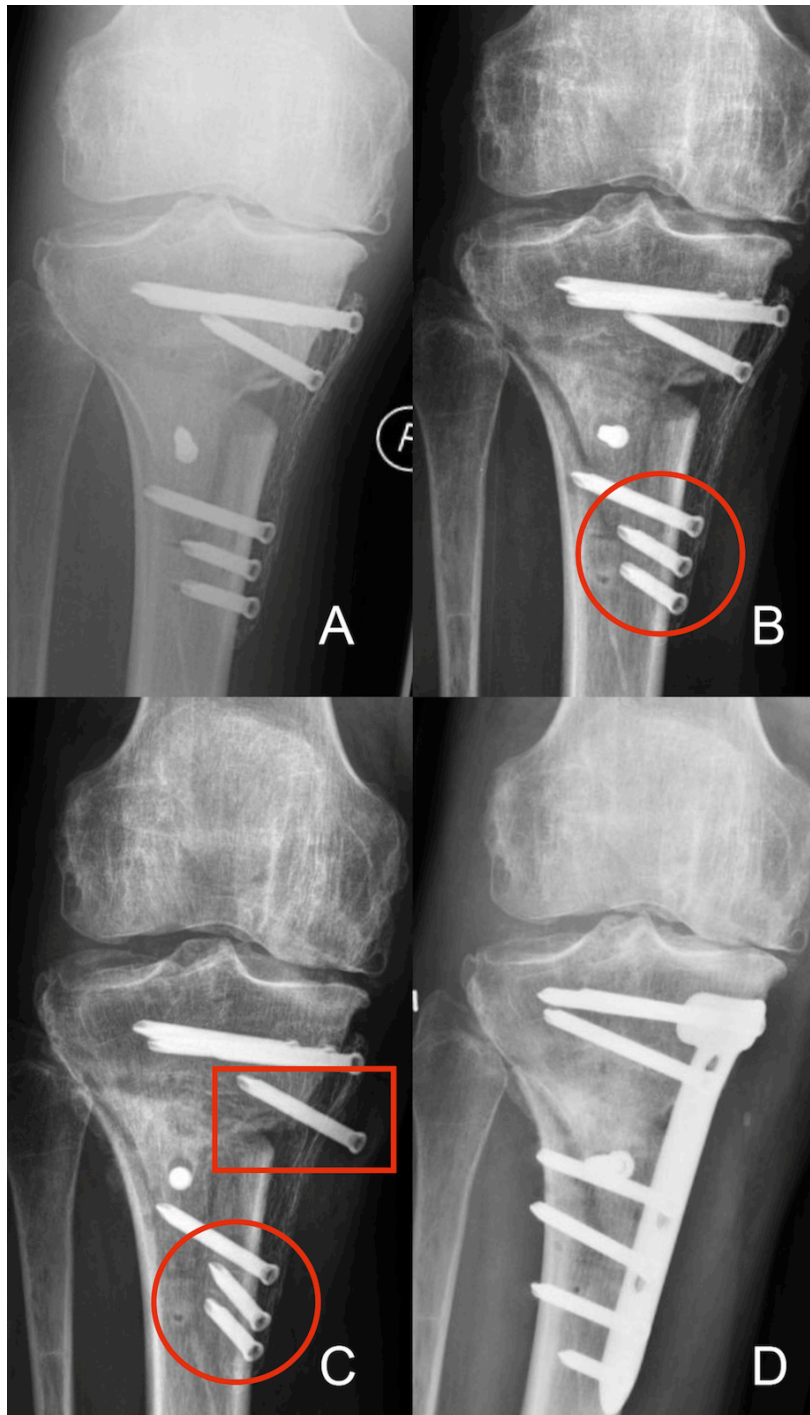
Postoperative AP radiograph at the inpatient stay (A) after ow HTO with the 2nd generation PEEKPower HTO-Plate® in a 49 year old sportsperson (height: 175 cm, weight: 76 kg, BMI: 25). The initial osteotomy gap in this case was 15 mm. Also minimal dislocation of the distal screws (red circle) was observed after he started bicycle training on the ergometer with 200 watts 6 weeks postoperatively (B). Afterwards, additional screw loosening of one of the most proximal screws (C, red oblong) with subsequent loss of the osteotomy gap was observed 3 months postoperatively. The patient was also successfully revised using the TomoFix™ plate, the osteotomy gap was additionally filled with autologous cancellous bone from the iliac crest and the mechanical axis was corrected. Removal of the TomoFix™ plate within complete consolidation of the osteotomy gap was done 18 months after initial ow HTO.
